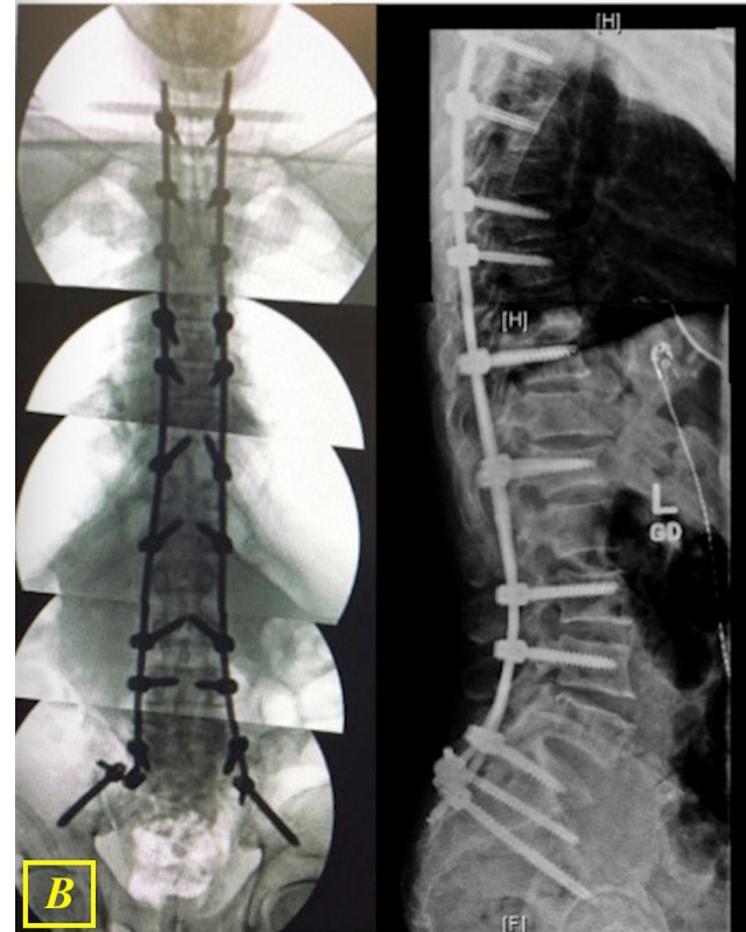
Post-operative AP and lateral radiographs of a 60-year-old male patient with multiple myeloma after a T1-Pelvis L-MIPPSF procedure. Patient had metastatic lesions in T2, T6, T9, T11 and L5.
